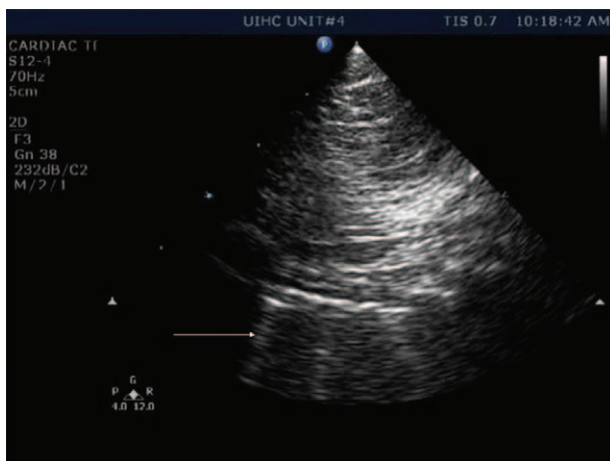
Still-frame example of B-lines (white arrow) on ultrasound.
